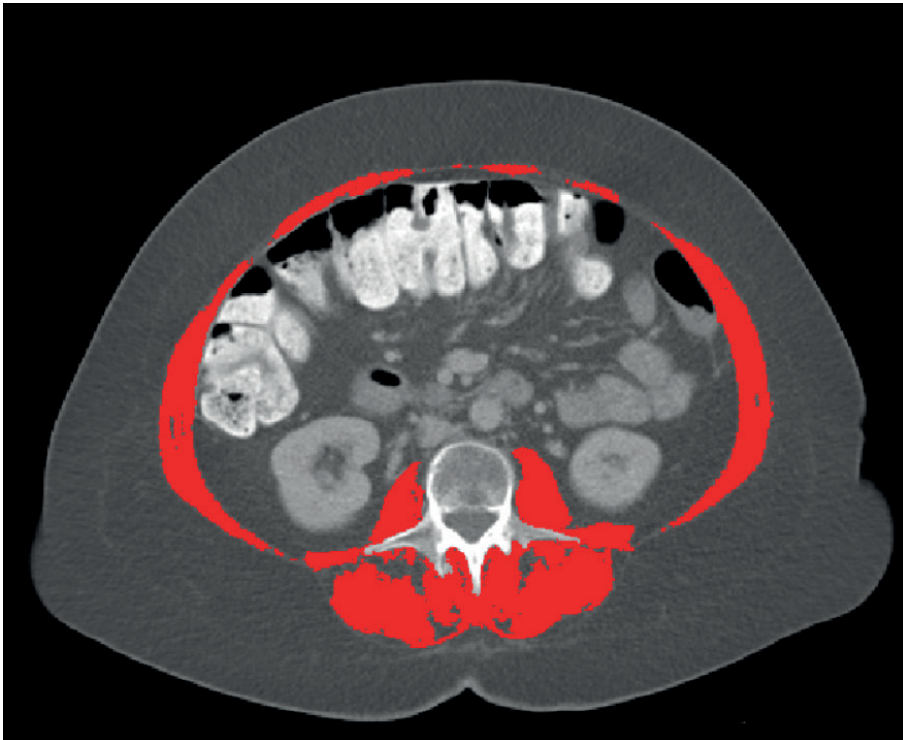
Abdominal axial CT scan of an ovarian cancer patient taken at the third lumbar level. Total skeletal muscle area in red.
